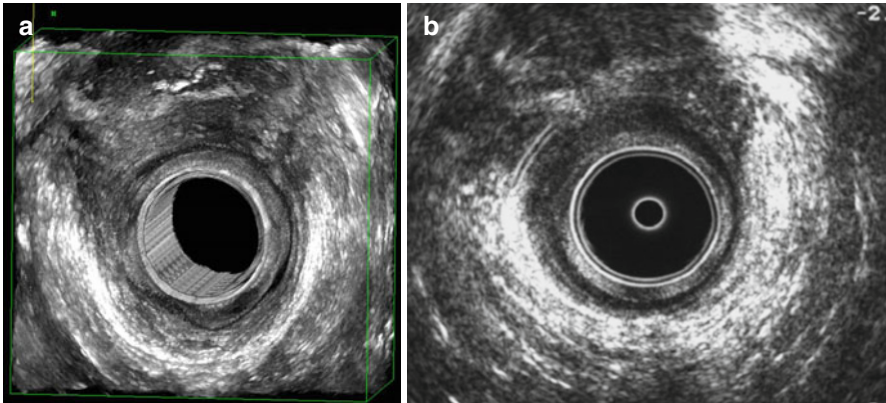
Endoanal ultrasound. (a, b) Anterior combined internal and external anal sphincter damage due to childbirth trauma
